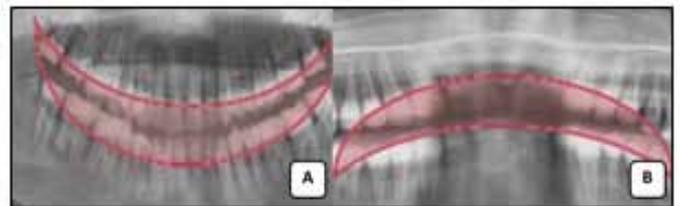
panoramic radiograph showing chin errors: (a) Chin tipped down (b) chin raised up. adopted from; Iannucci and Howerton (Iannucci, 2017).
